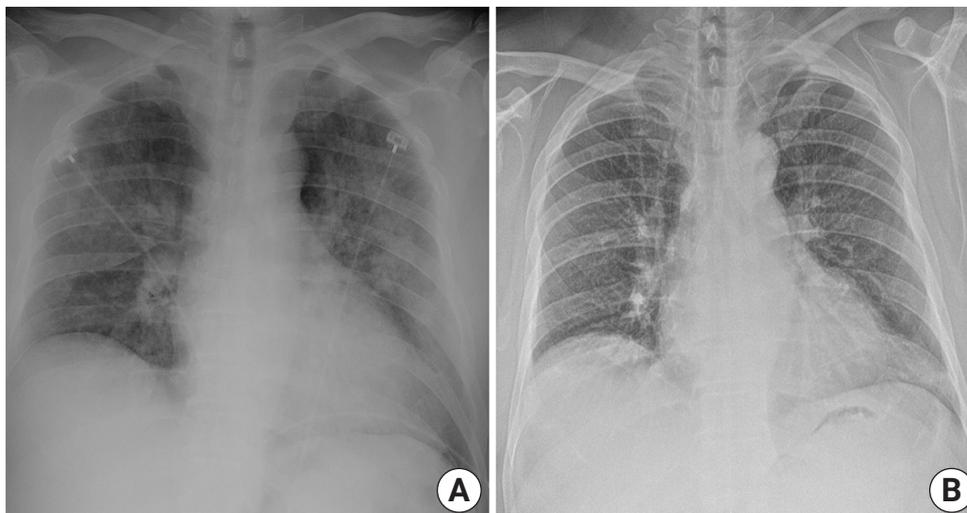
Chest radiograph. (A) Initial chest X-ray demonstrates diffuse bilateral opacities. (B) At hospital discharge, chest X-ray showed marked improvement.
